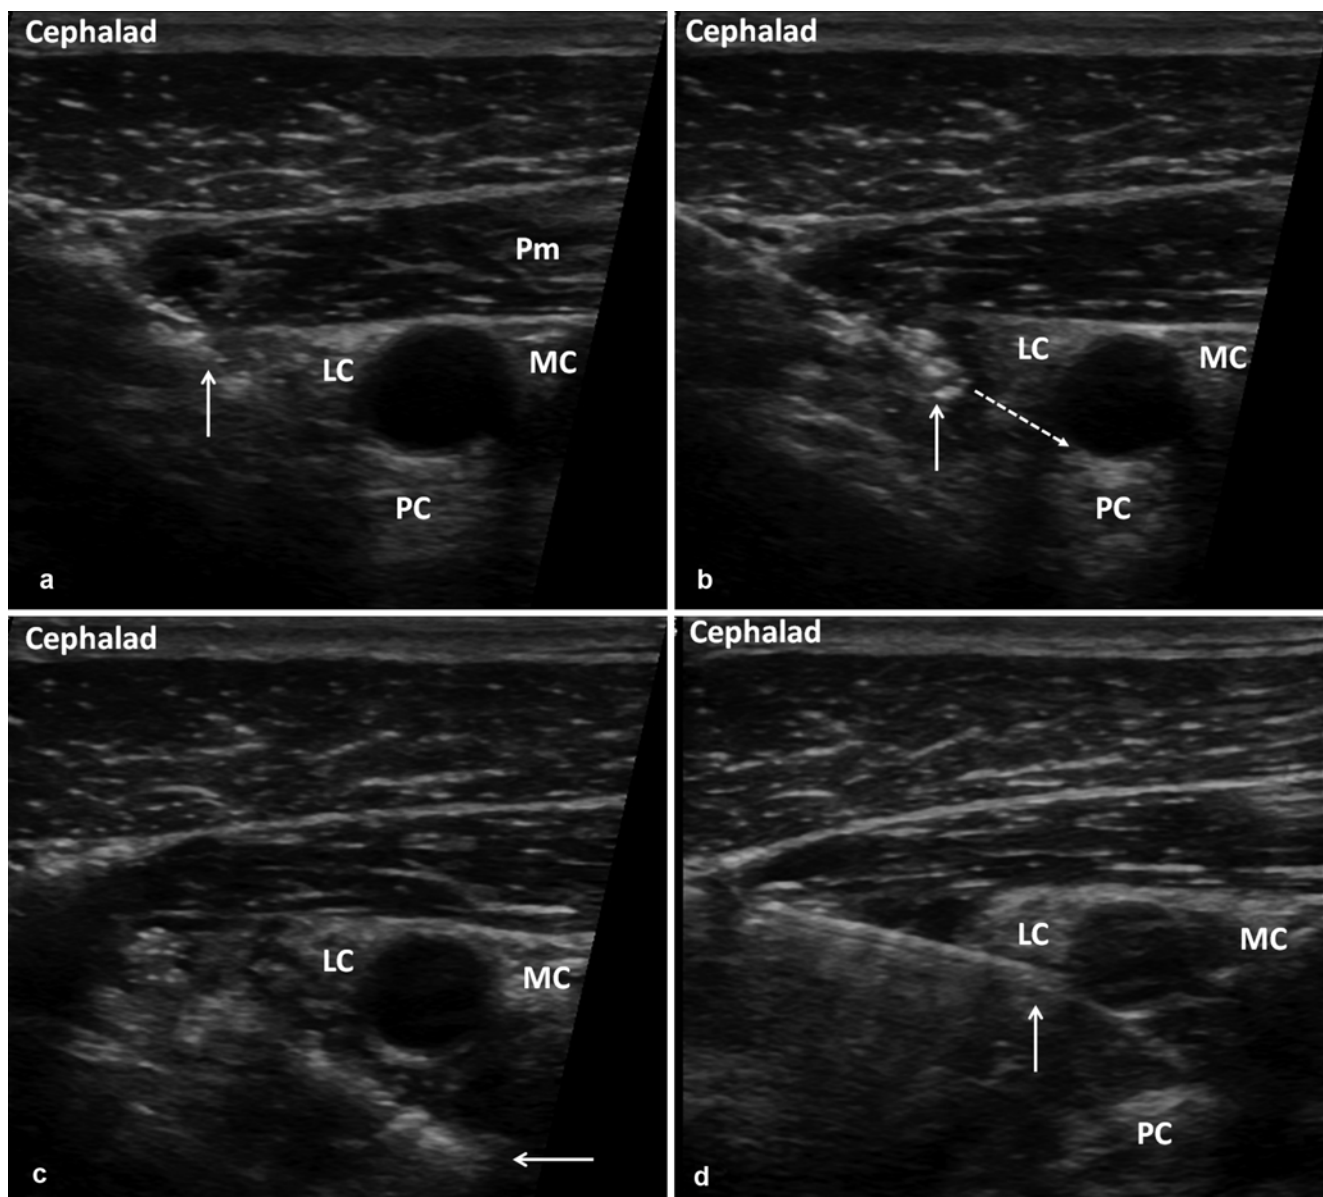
Typical performance of an ultrasound-guided infraclavicular block. (a) The needle tip (*arrow*) pierces the deep fascia of pectoralis minor (*Pm*), just lateral to the lateral cord (*LC*). (b) 0.5–1 ml of fluid is injected to confirm that the needle tip is in the correct compartment and to push aside the lateral cord so that the needle can reach the posterior aspect of the artery (*dotted arrow* indicates trajectory). (c) Injection at
